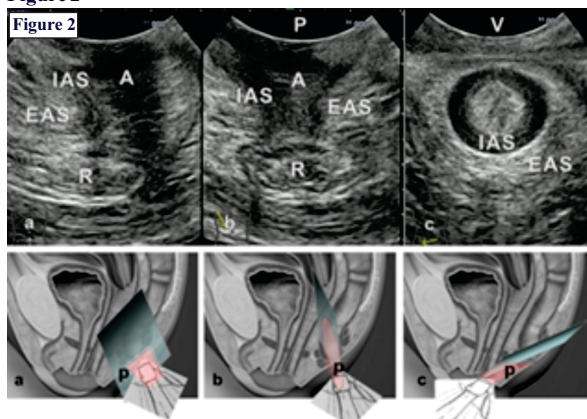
Sagittal (a), coronal (b) and transverse or axial (c) approaches of the anus with its sonographic views.
